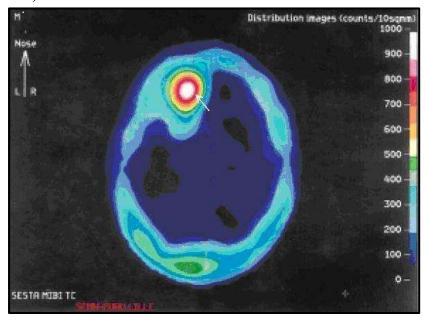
Axial tomoscintigraphic slice showing abnormal uptake of 99m Tc Sestamibi next to the left frontal region (arrow) in favor of tumor recurrence. (Habib Allah., 2008).
